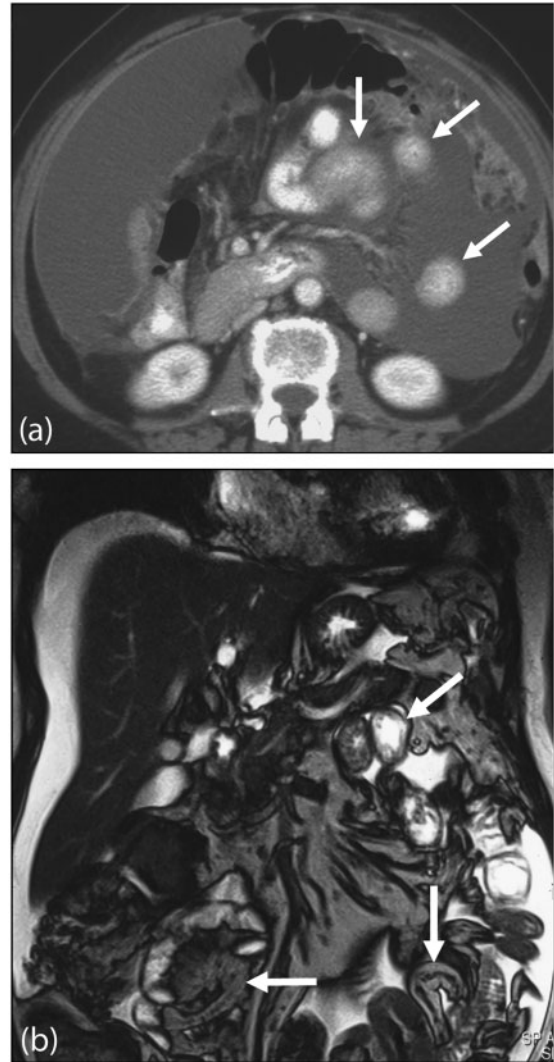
Serosal deposits. (a) Axial contrast-enhanced MDCT shows small bowel serosal deposits from metastatic ovarian carcinoma (arrows). Note involvement of the greater omentum and extensive ascites. In a different case, (b) coronal T2-weighted MRI demonstrates multisegment small bowel serosal deposits (arrows).
